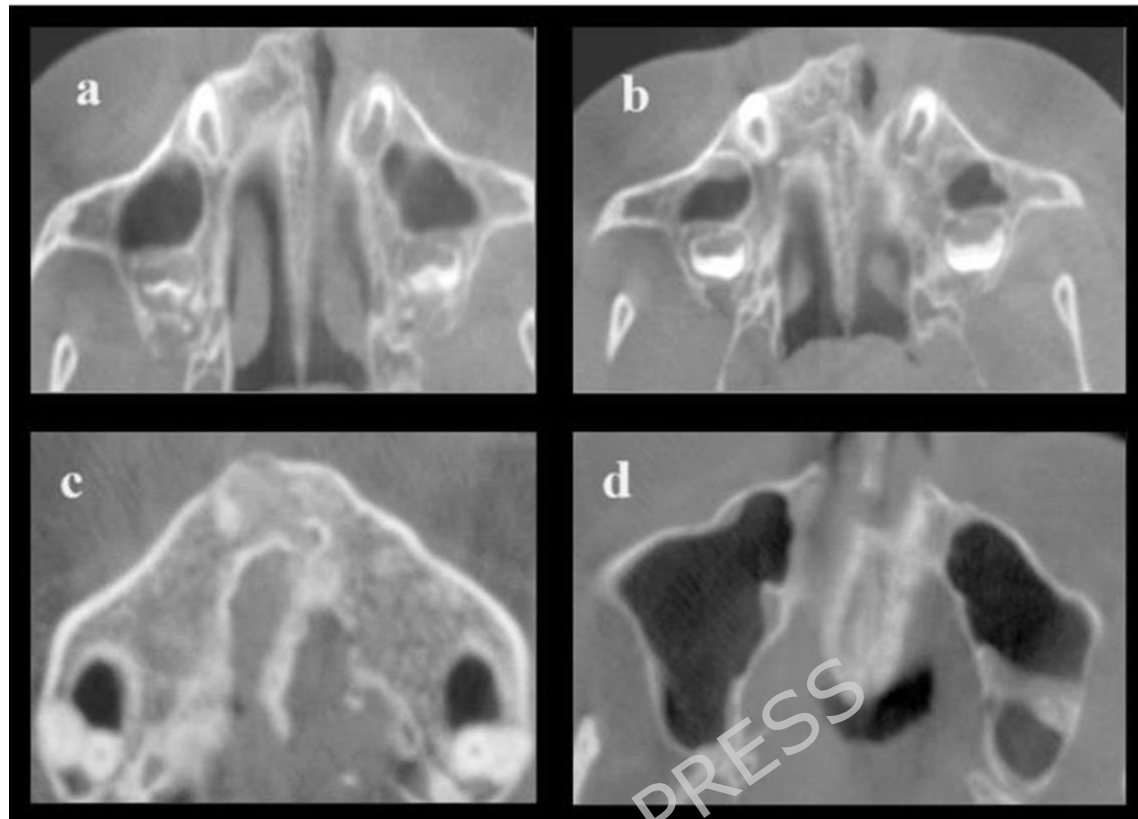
(b) CBCT axial view showing MPS maturation stage E.
